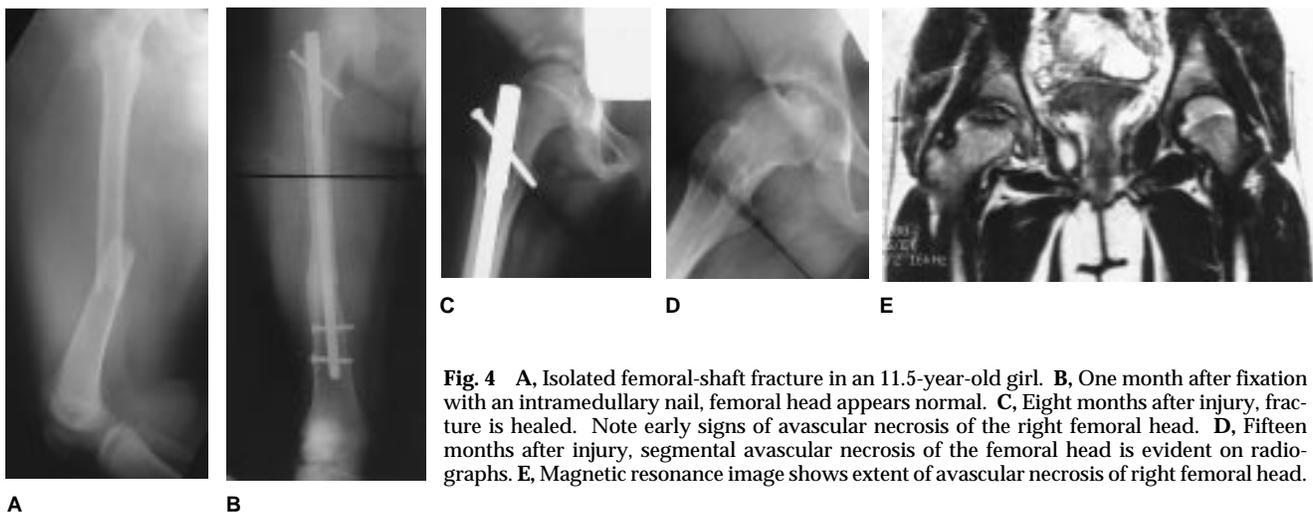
A, Isolated femoral-shaft fracture in an 11.5-year-old girl. B, One month after fixation with an intramedullary nail, femoral head appears normal. C, Eight months after injury, fracture is healed. Note early signs of avascular necrosis of the right femoral head. D, Fifteen months after injury, segmental avascular necrosis of the femoral head is evident on radiographs. E, Magnetic resonance image shows extent of avascular necrosis of right femoral head.
